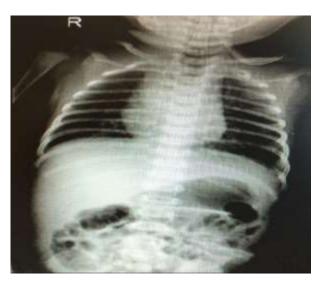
X-ray shows coiling of feeding tube in upper pouch.
